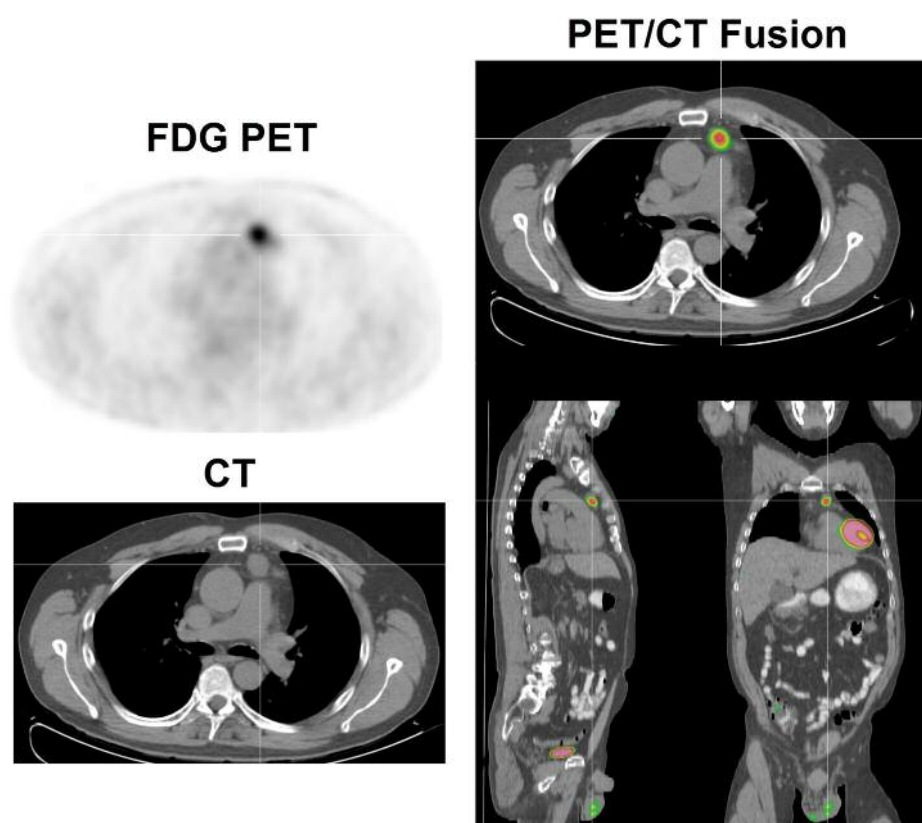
Positron emission and computed tomography images, with crosshair over the mediastinal cholesterol granuloma.
